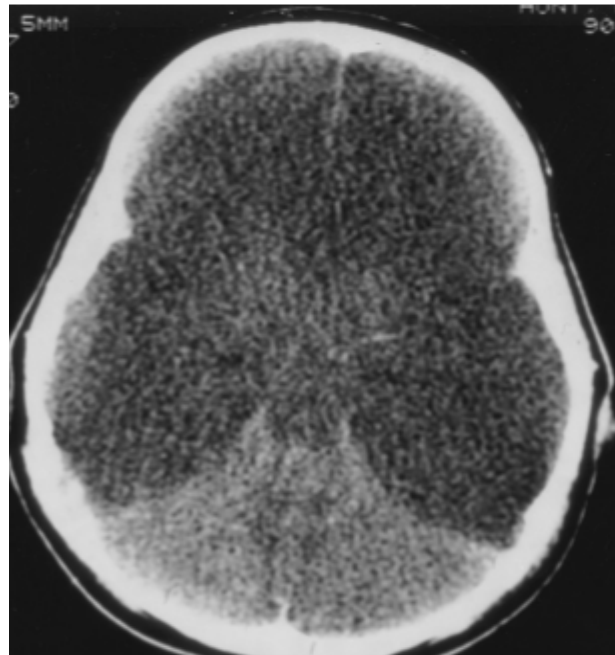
Computed tomography of the brain in children with fulminant hepatic failure. (A) Mild CE with the reversal sign pattern. The cortical gray and white matter is hypodense but the deep gray structures and cerebellum are of normal density. The ventricles and cisterns are patent. (B) CE with the reversal sign, obliteration of the cisterns, and compression of the lateral ventricles. The deep gray structures have a normal appearance. (C) Profound CE with loss of the prominent reversal sign because the deep gray structures are now hypodense; the ventricles and cisterns are totally compressed and not visible.
